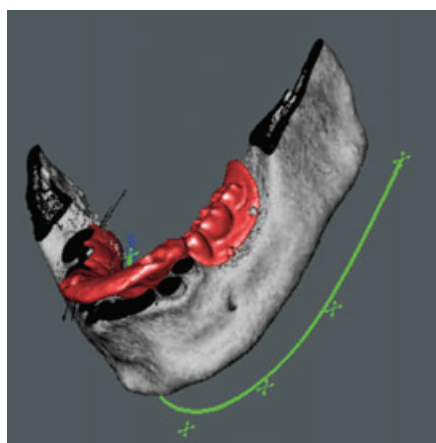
Lateral view, posterior mandible, with radiographic guide.
